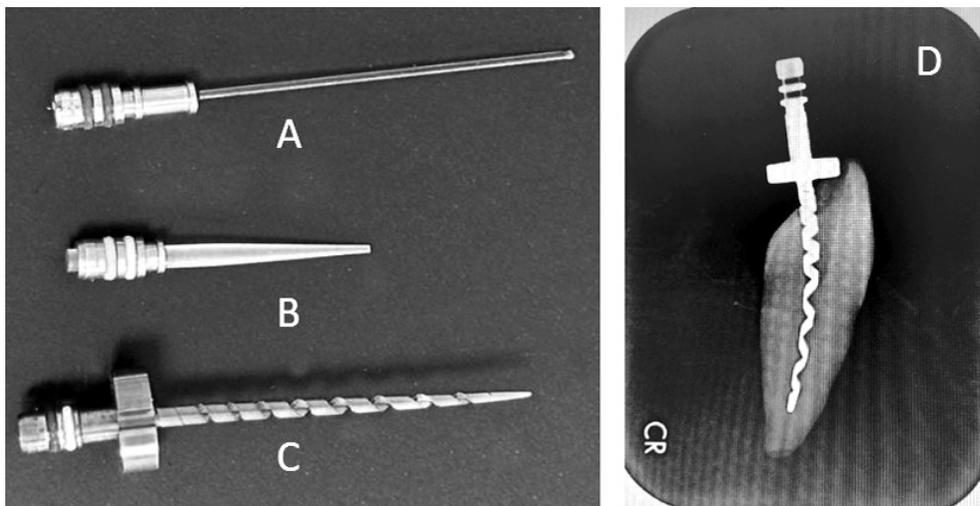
The available endodontic tips - cylindrical quartz fiber tip (A), Endo tip LIFG4001A (B) and Sapphire tip AS7075X (C) revealed different designs that interfere with their effectiveness. X-ray of the Endo tip LIFG4001A inserted into root canal (D).
